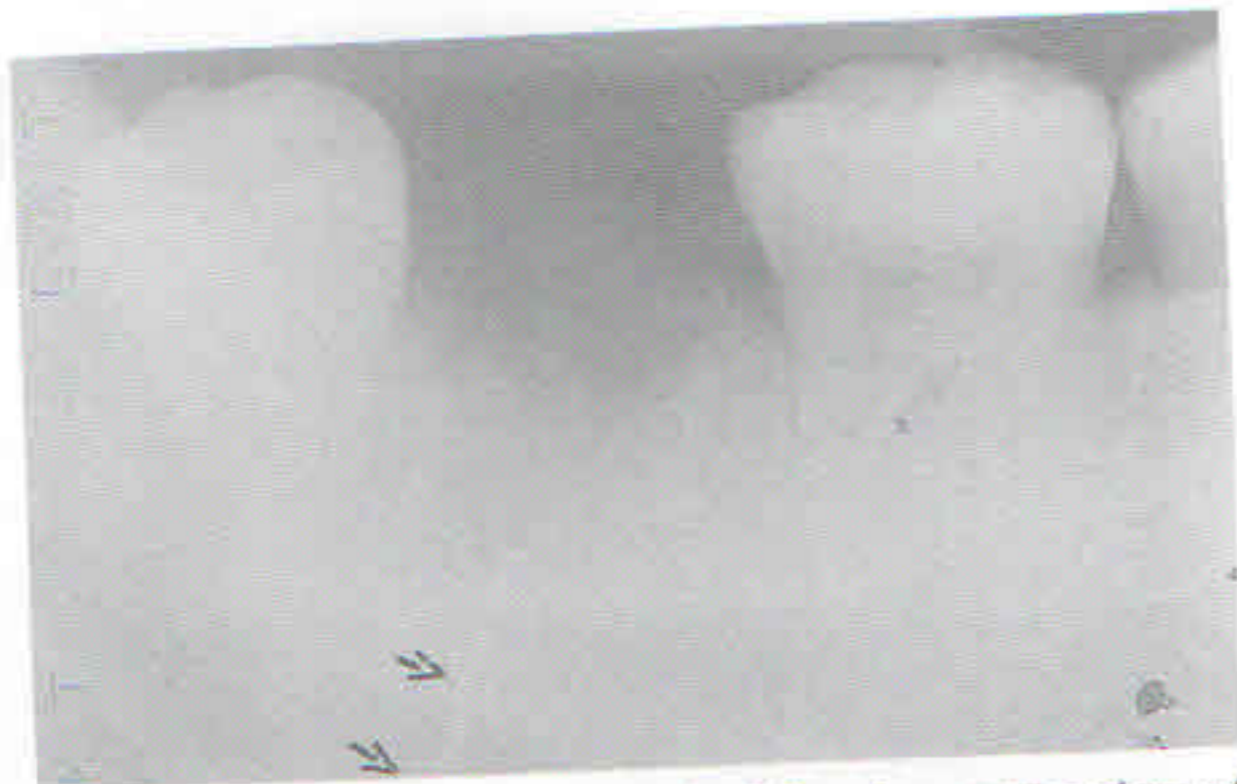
Periapical radiograph following extraction of lower right second molar showing the embedded root filling material and the separated instrument lying in the inferior dental canal (arrows).
